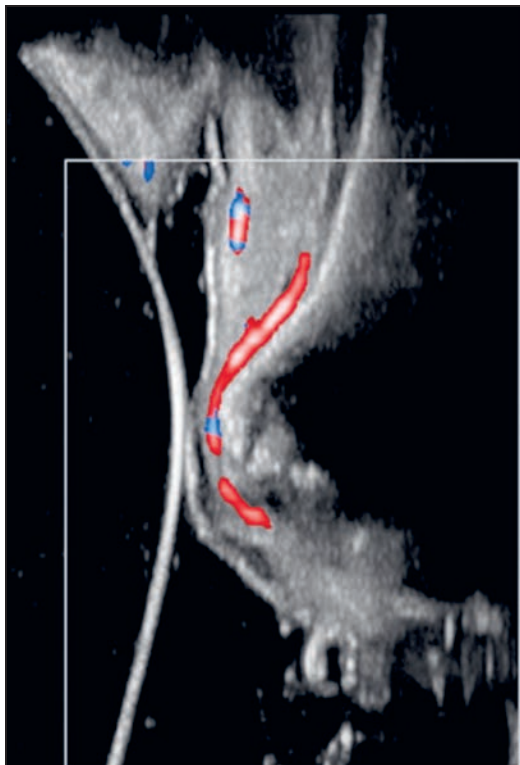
Example of blood-flow visualization using an ultrasound image and color flow mode of an edentulous crest from a facial (cross-sectional) view. Red and blue pixels are superimposed on gray brightness-mode pixels to detect the velocity of the blood flow. A positive velocity toward the transducer is typically displayed in red/yellow. Blue/cyan pixels are labeled as negative and indicate a velocity moving away from the transducer. Ultrasound imaging can be useful for locating suprapariosteal arterioles (SPAs), viewed as red or blue hues.
